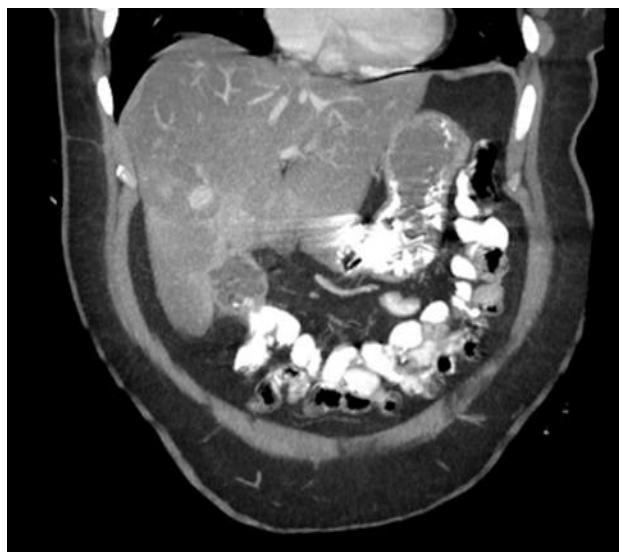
Axial abdominal computed tomography scan in portal venous phase after administration of oral contrast demonstrates fistulous communication between the gall bladder and hepatic flexure. The enteric contrast is noticed in the GB lumen.
